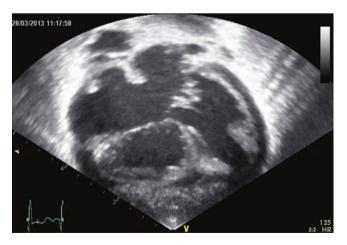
Echocardiographic image: ostium primum atrial septal defect, 2D
